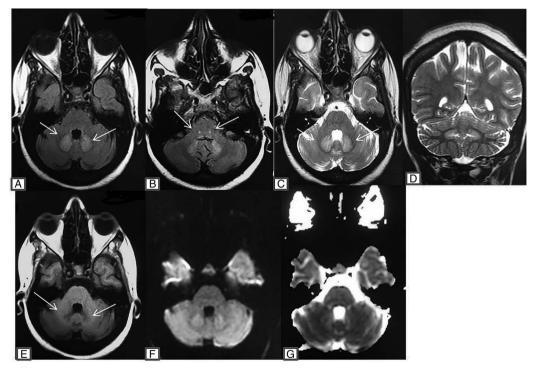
MRI reveals symmetric area of T2-weighted imaging and fluid-attenuated inversion recovery hyperintensity involving bilateral dentate nuclei and deep cerebellar white matter (white arrow in A and C and D) and bilateral superior olivary nuclei in dorsal pons (white arrow in B). The corresponding areas appearing hypointense on T1-weighted imaging (white arrow in E). No evidence of restricted diffusion seen on diffusion-weighted imaging and apparent diffusion coefficient map (F and G).
